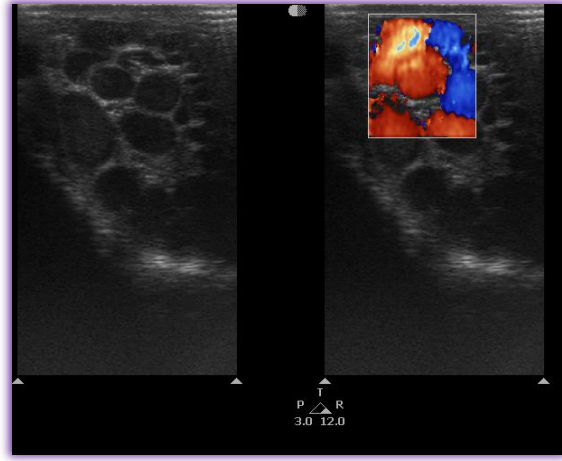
Transverse scan and colour Doppler in another case showing dilated pampiniform plexus of veins. (Case 29)
